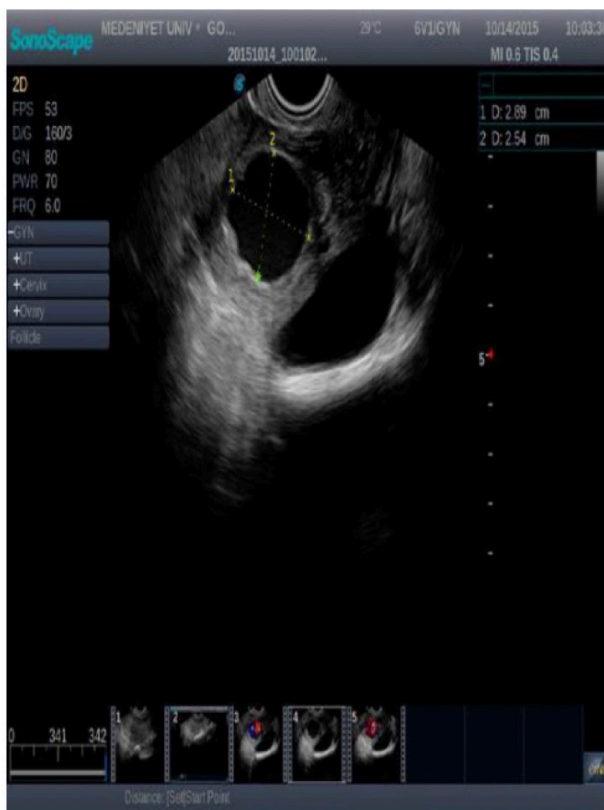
Ultrasound image of the uterine AVM at the time of diagnosis.
